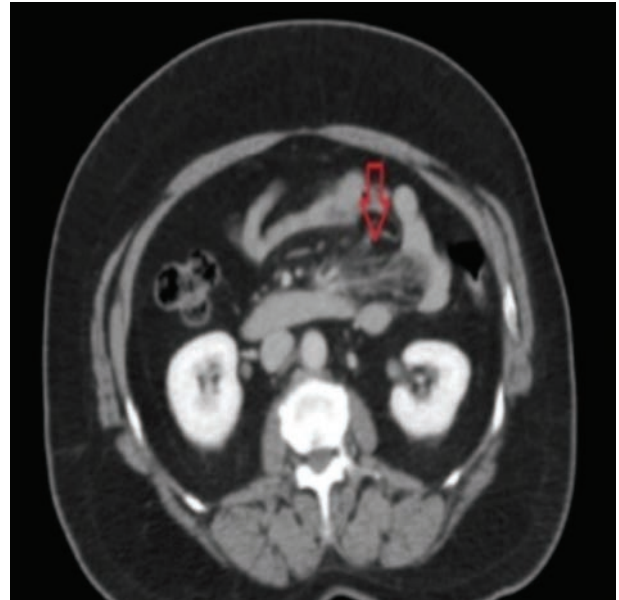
The CT image shows a retractile panniculitis. In this case the fibrotic portion of the mass cause an important retraction on the adjacent small bowel (red arrow). The description of small bowel retraction due to fibrotic mesenteric panniculitis is the most important aspect of the disease because it can influence the prognosis and treatment of the disease in relation to the symptomatology of intestinal obstruction
